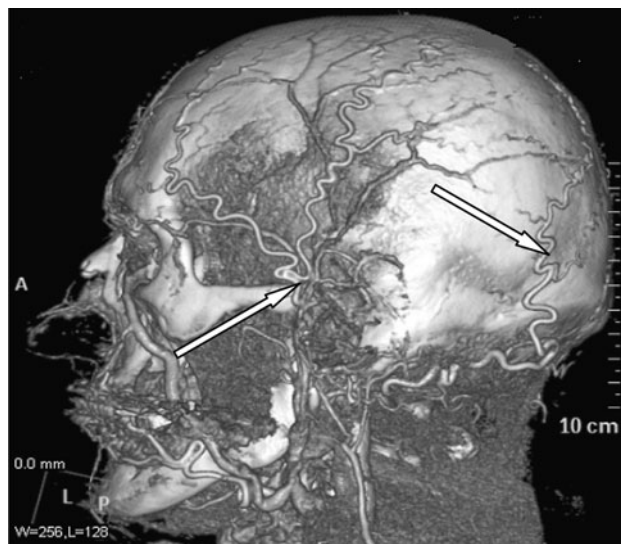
CT angiogram showing the superficial temporal and occipital arteries which form the basis of Wolff's theory of extracranial vascular pain
